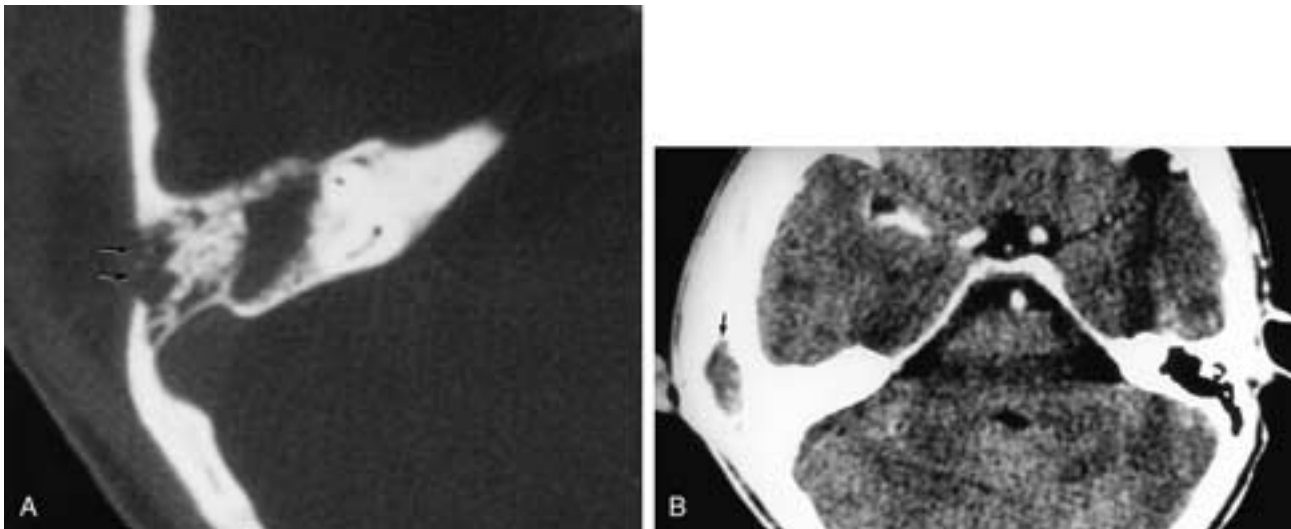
Coalescent mastoiditis with subperiosteal abscess. A, Axial CT, right ear. Poor definition of mastoid septae, with a large defect in the external mastoid cortex (arrows). B, Palpable postauricular mass of low CT density (arrow). At surgery, an abscess pocket was found emanating from this site. (Courtesy of Dr. Roy A. Holliday).
